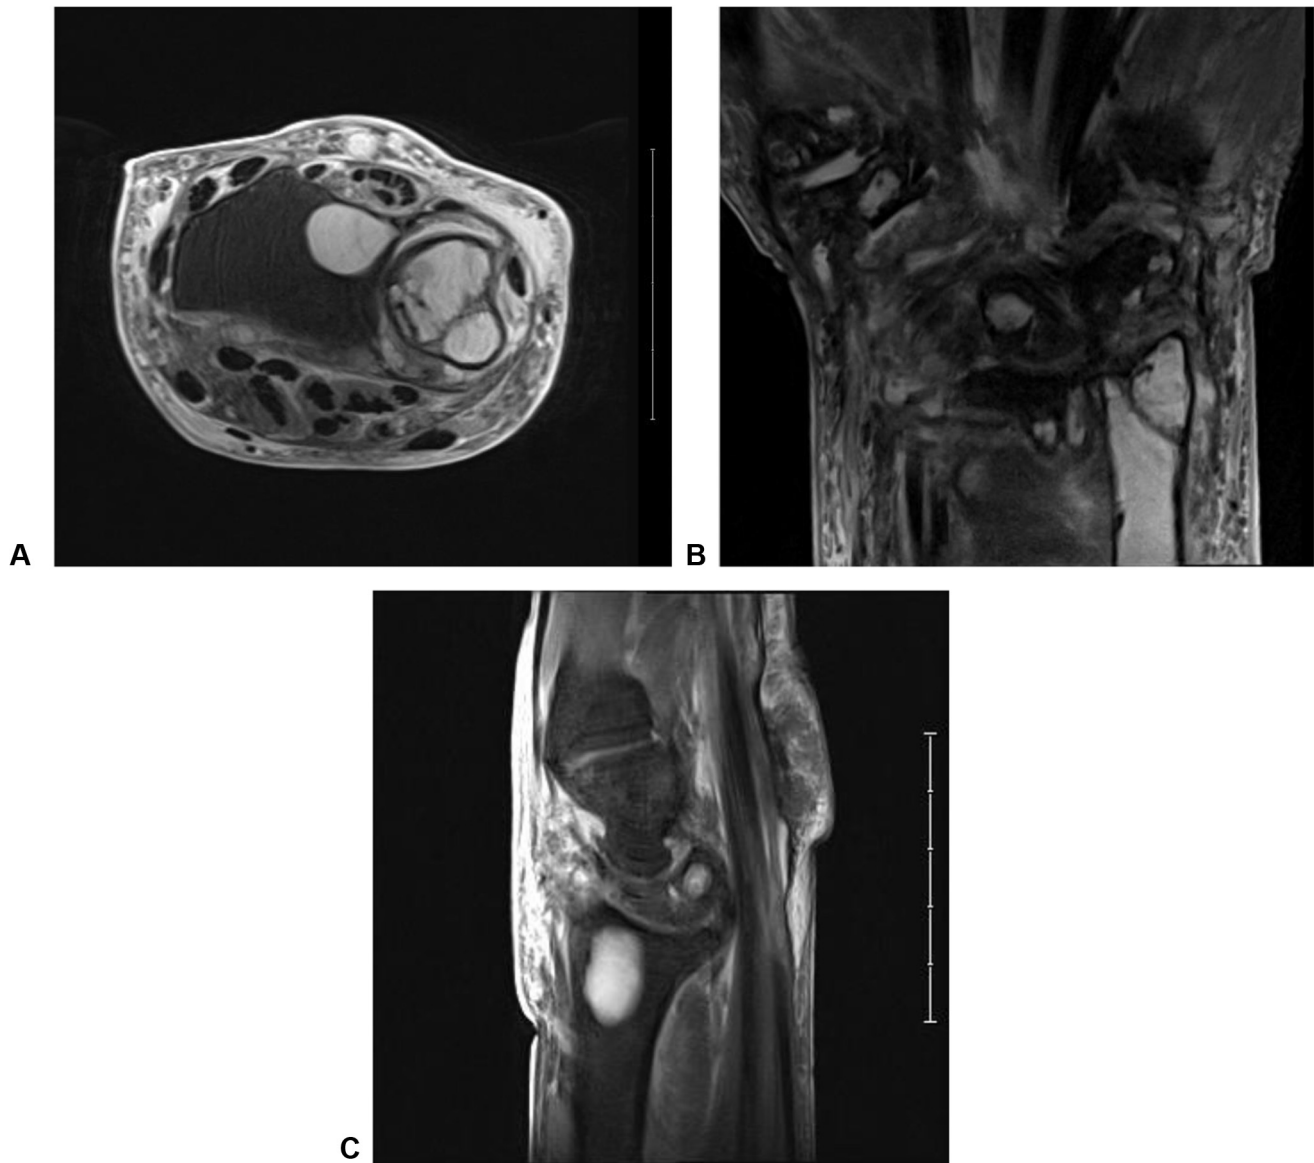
T2-weighted axial, coronal, and sagittal magnetic resonance images demonstrating a septated, hyperintense lesion within the medullary cavity of the distal ulna and a well-demarcated, hyperintense lesion of the ulnar aspect of the intramedullary canal of the radius.
